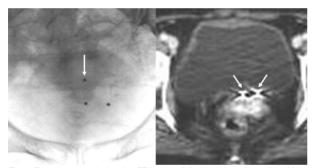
Fluoroscopy and planning CT image of three gold markers placed in a patient.
